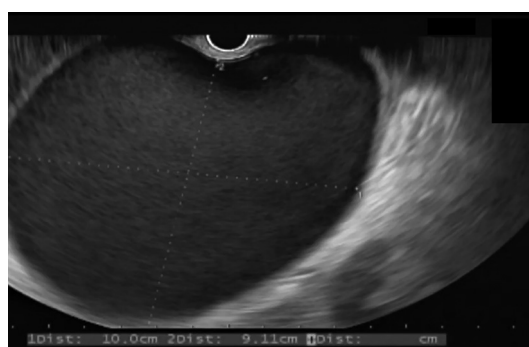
Endosonography view of a cystic peri-pancreatic lesion measuring 9/10 cm with hypoechoic content, with no fibrin septations (48 hours after Alteplase injection).
